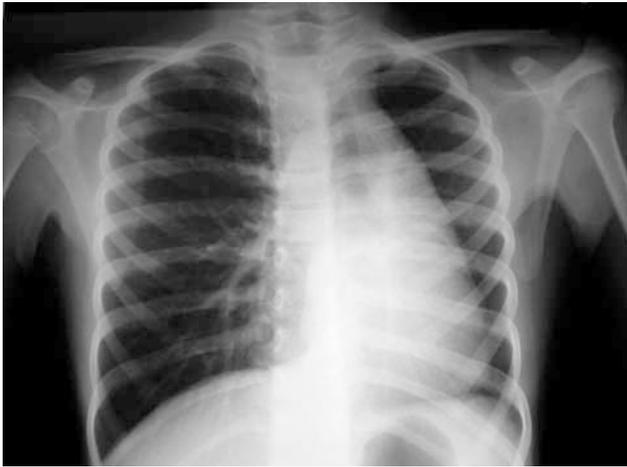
Chest radiograph shows reduction in perfusion and volume of left lung with mediastinal shift to the same side (Case 1).
